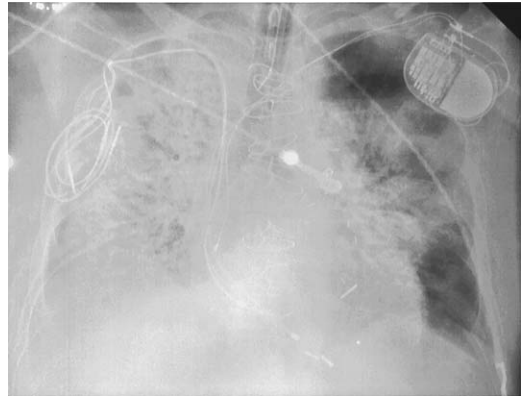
A 65-year-old man who has pulmonary edema and DAD secondary to amiodarone. Portable chest radiograph shows alveolar infiltrates and consolidation involving the right lung diffusely and the left in a perihilar distribution.
